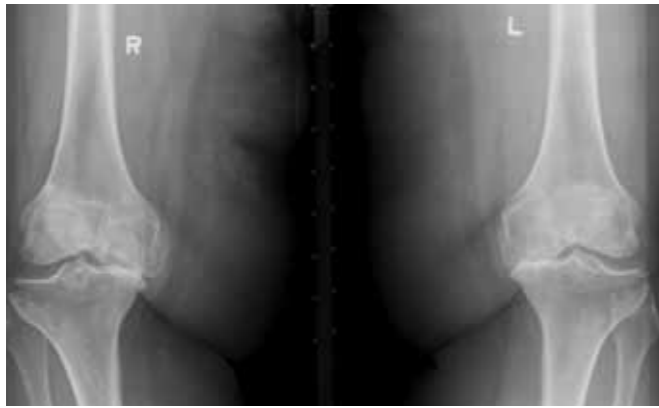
x-ray showing severe knee osteoarthritis
